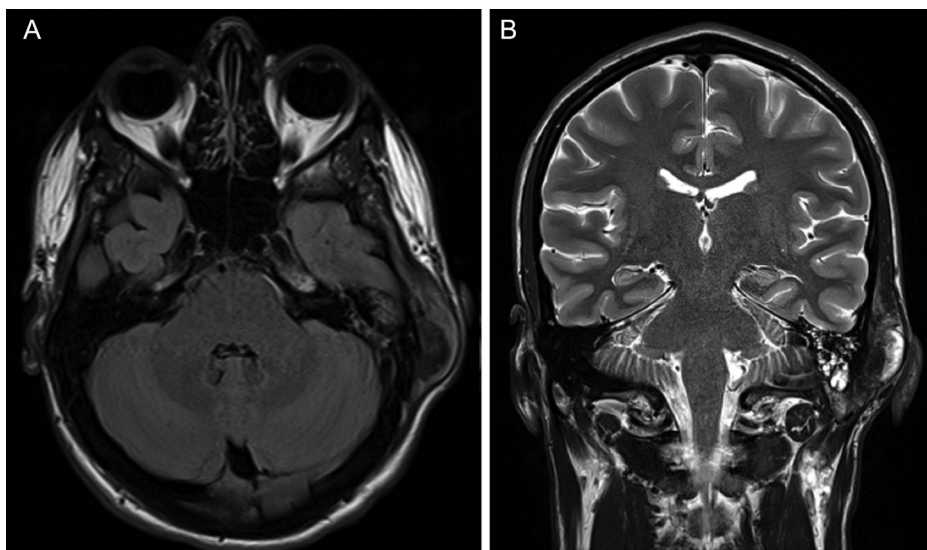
Preoperative magnetic resonance imaging. (A) Axial T1-weighted image showing the temporal bone lesion with heterogeneous signal intensity. (B) Coronal T2-weighted image showing the tumor cephalo-caudal extension up to 50 mm.
